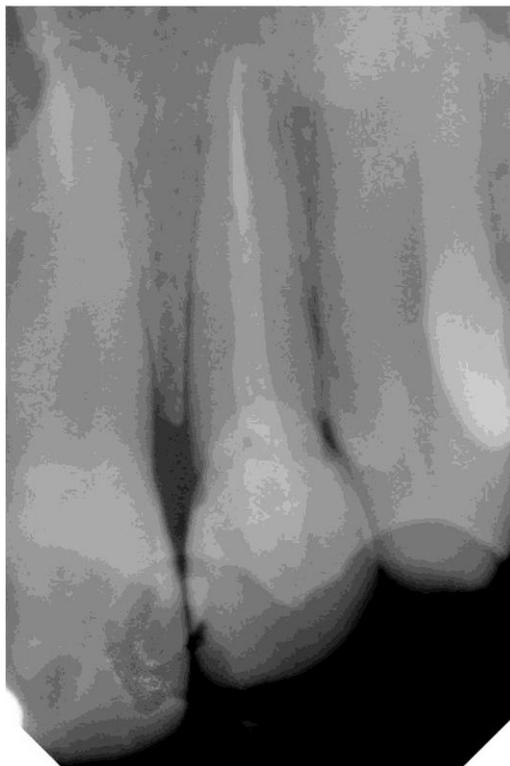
Periapical radiograph after 12 months of follow up not showing any abnormality
